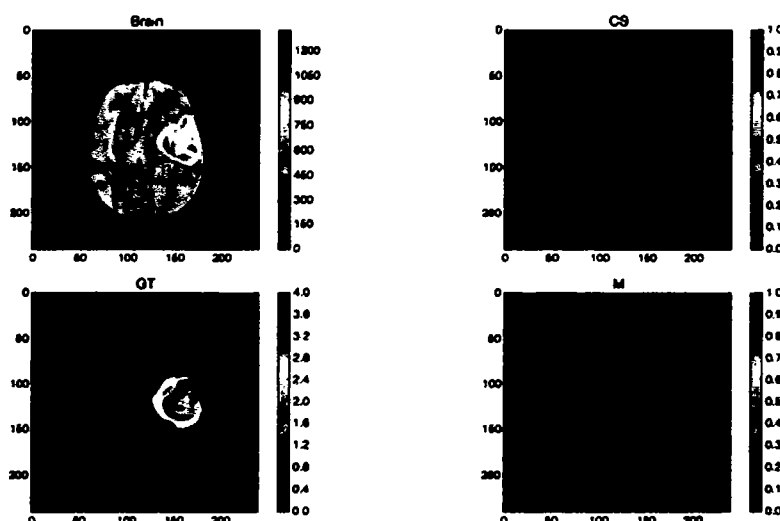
FLAIR MRI confidence surface
